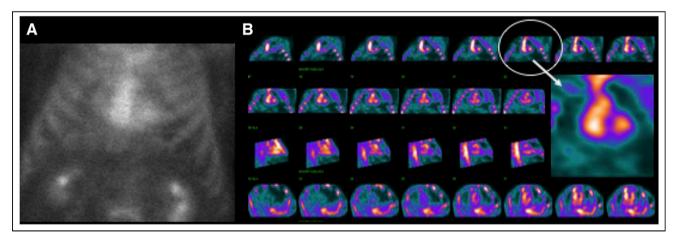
Planar vs. SPECT blood pool. On planar ^{99m}Tc-pyrophosphate images, blood pool cannot be differentiated from myocardial uptake. (A) Anterior planar image demonstrating diffuse uptake assumed to be myocardial uptake. Planar-only imaging cannot be used to differentiate blood-pool uptake from myocardial uptake. (B) SPECT images immediately after acquisition of planar images showing that ^{99m}Tc-pyrophosphate uptake is not localized to myocardium but is within ventricular cavity blood pool. Circle denotes coronal image best demonstrating residual blood pool. (Reprinted from (1).)
